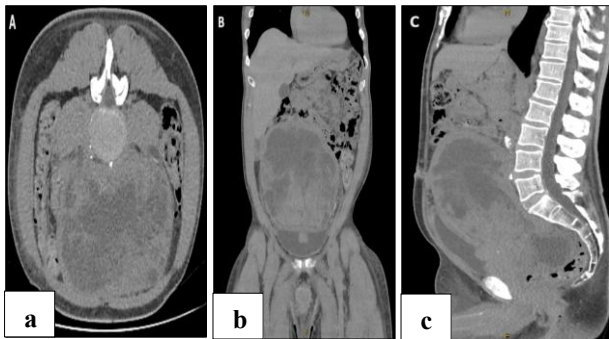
CT images demonstrating large, heterogeneous pelvic mass – (a) axial, (b) coronal, and (c) sagittal.
